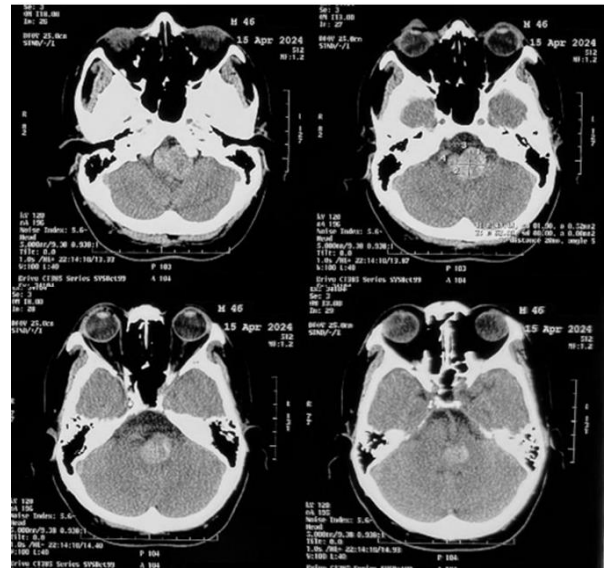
Initial non-contrast CT scan at the referring hospital revealing a hyperdense lesion between the cerebellum and brainstem, initially suspected as a hemorrhagic event.
